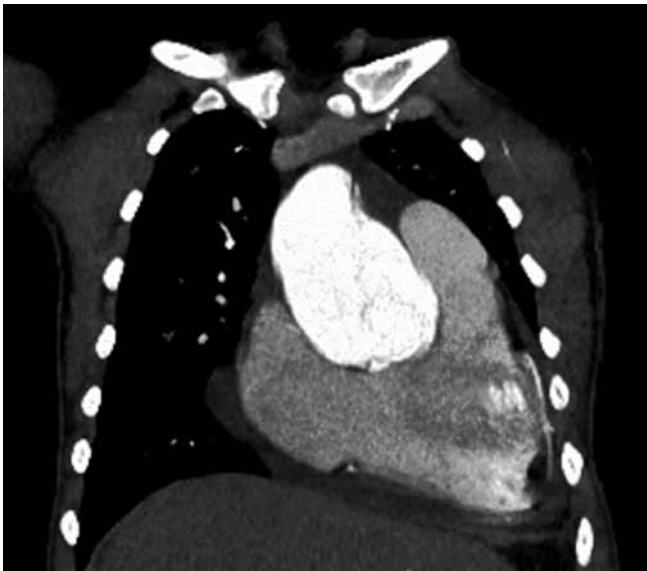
Contrast-enhanced chest CT scan, lumen of the ascending aorta
